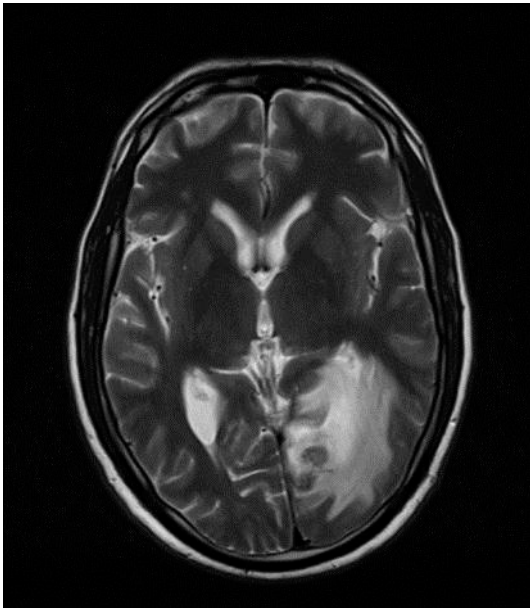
On brain MRI (T1, T2), the space-occupying lesion is evident in the left occipital lobe.
